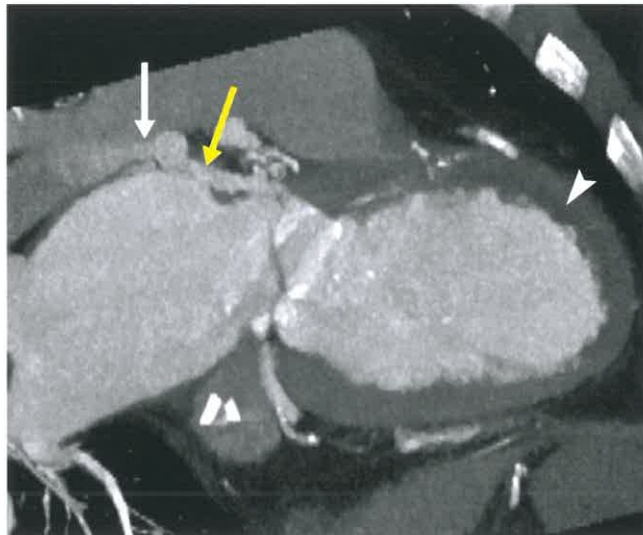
Coronary Artery Fistula. Sagittal oblique multiplanar reformat from a retrospectively gated coronary CTA showed diffuse tortuosity and dilation of the LCx (yellow arrow), a portion which drains into the left pulmonary artery (white arrow). The LAD territory shows subendocardial hypoperfusion (white arrowhead).
